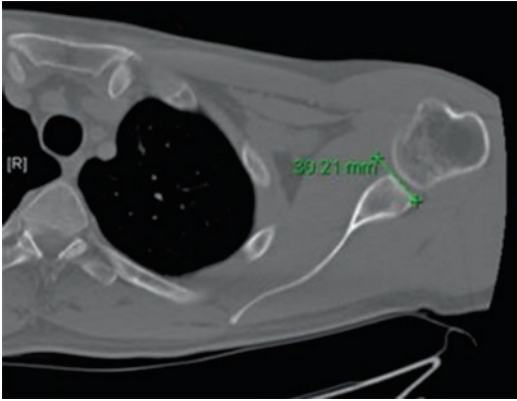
Axillary CT scan image showing measurement of the glenoid to estimate bone loss
